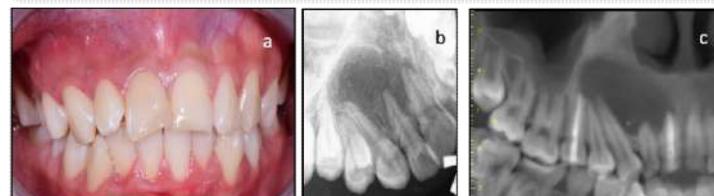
(a) The oral examination shows a buccal gingival swelling with a sinus opening in the area of tooth 13-14. (b) The topographic radiograph shows a large radiolucent area covering the apex of teeth 11-15. (c) Cone Beam Computed Tomography (CBCT) images reveal that the center of the lesion is located at tooth 12-13, which still responds to the vitality test.
